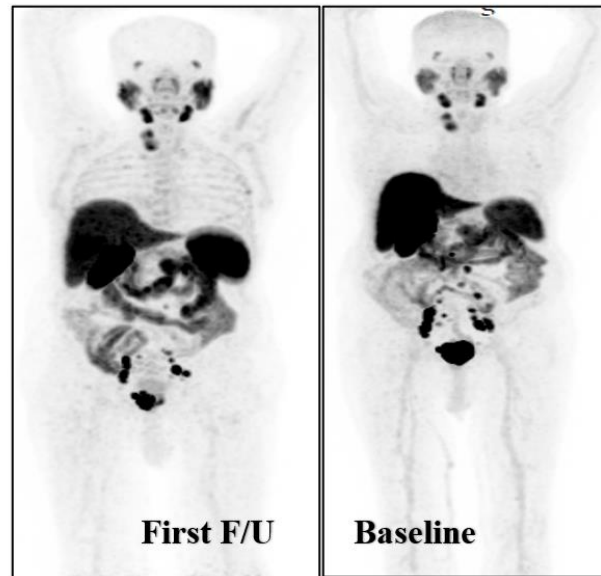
MIP of post-therapy PSMA-PET/CT study of case 1.
